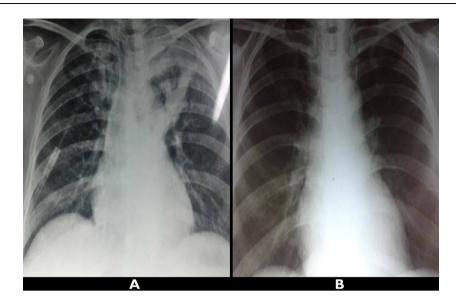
Chest X-ray PA view showing Y-shaped linear non-homogenous opacity in the left upper zone (A) as compared to previous X-ray (B).
